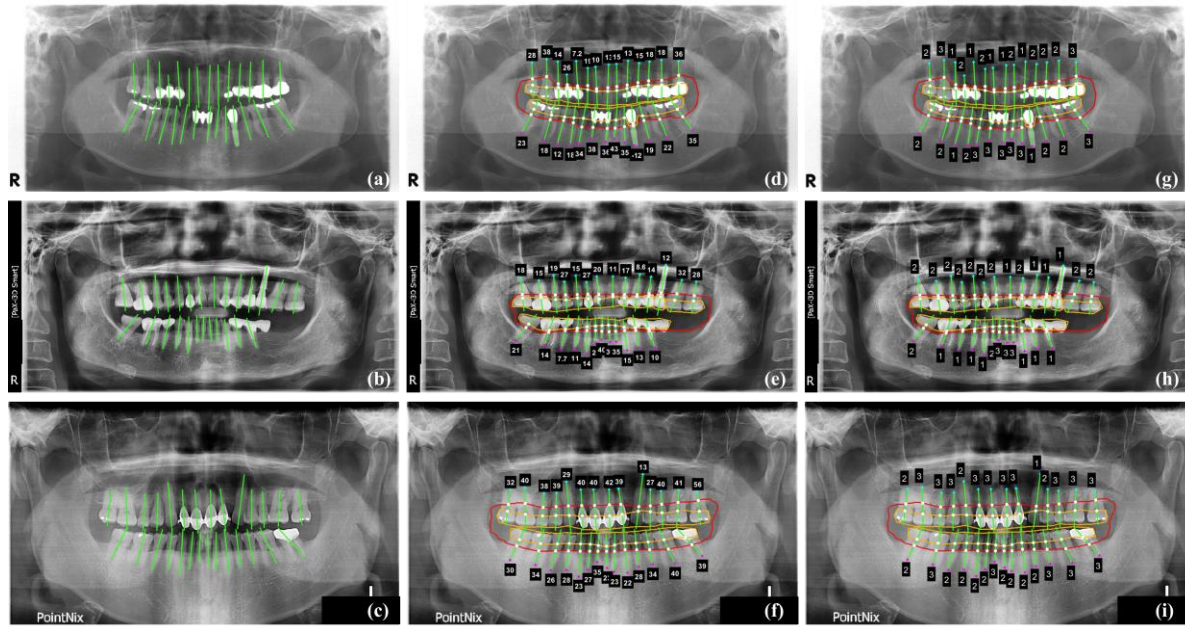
The long-axis orientations of the tooth and the implant (a-c), the intersection points of the tooth (implant) long-axis with the periodontal bone level (PBL) and the cemento-enamel junction level (CEJL) (fixture top level), the percentage rate of the radiographic bone loss (RBL) (d-f), and the stages of the periodontitis for each tooth and implant (g-i). The first, second, and third rows are images from device 1, device 2, and device 3, respectively
